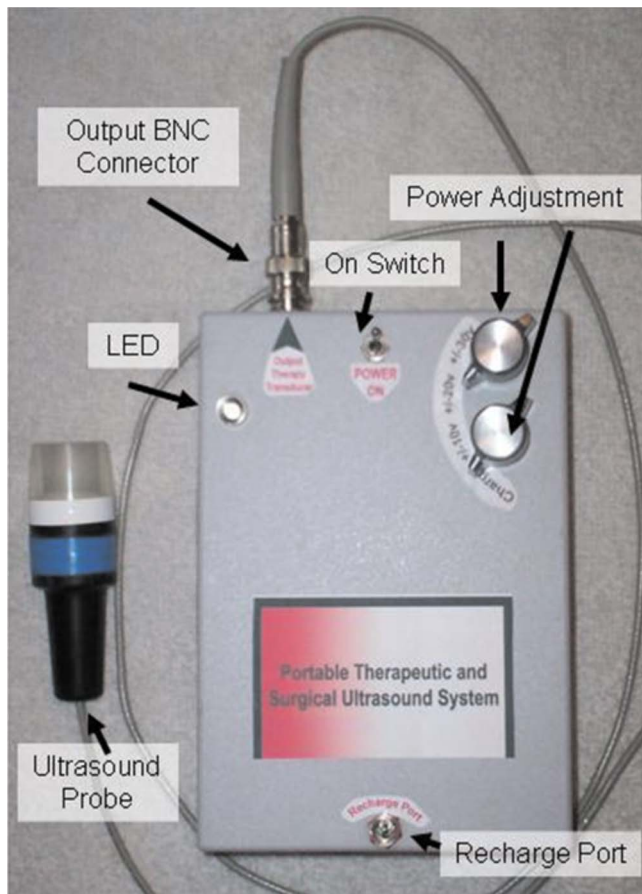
(Color online) Portable therapeutic ultrasound system with 1.54 MHz ultrasonic probe. The unit is  $4 \times 6 \times 2$  in.<sup>3</sup> and weighs 5.5 lbs.
